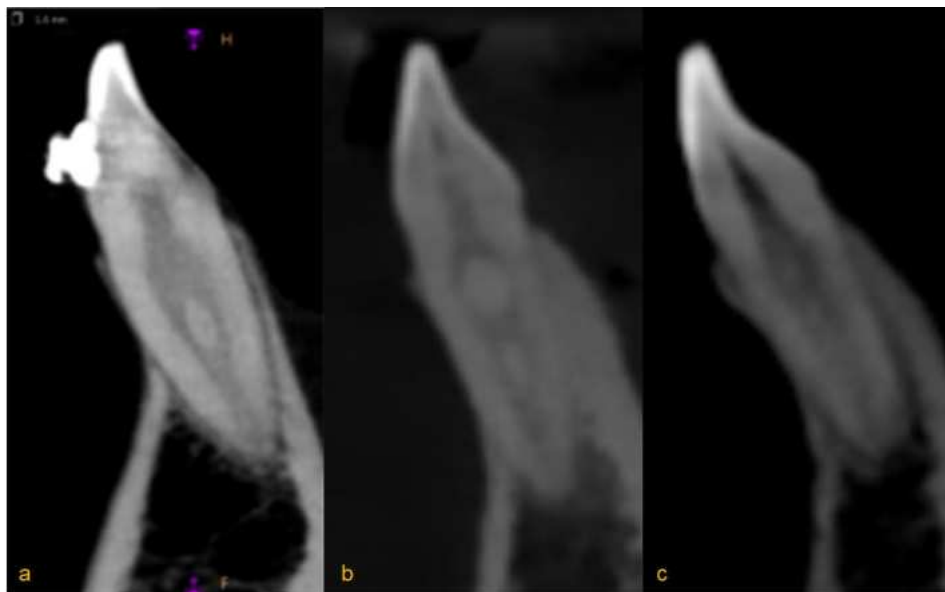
Representative images of the anatomical variations seen on CBCT sagittal view, ¹⁴²1-2-1-2-1 (a), ¹⁴²2-1-2-1 (b), and ¹⁴¹1-2-1-2-1 (c).
